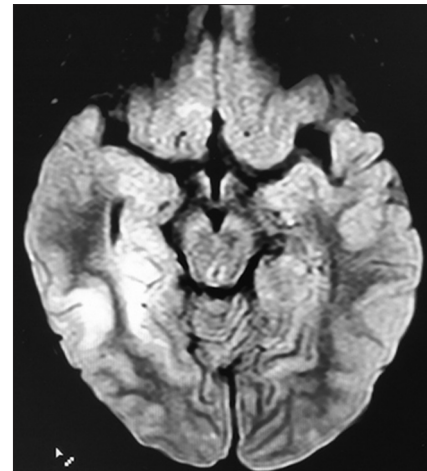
(a and b) Magnetic resonance imaging brain of the child at the time of presentation -diffusion-weighted image and analog-to-digital converter showing restriction of diffusion in the right temporal lobe
